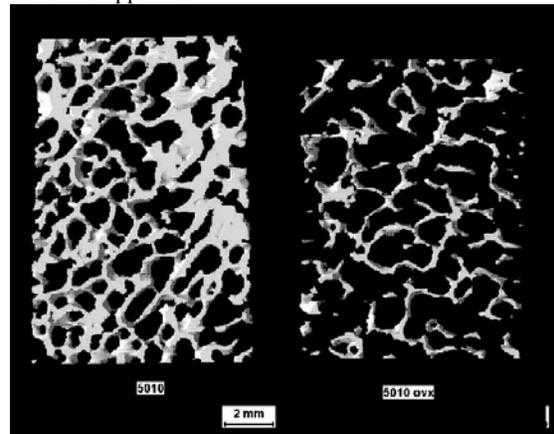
3D μ CT scan image of bone (iliac crest) before and 6 month after ovariectomy
